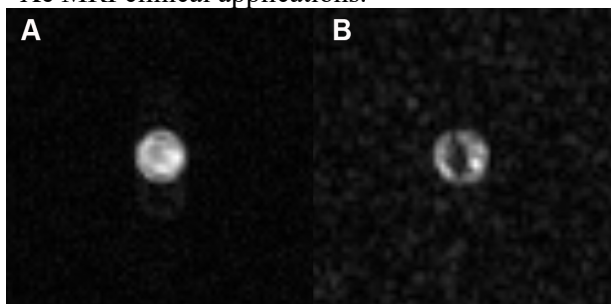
Two consecutive 2D axial ^{129}Xe MRI images. SNR of (a) is 80 and for (b) is 10.
